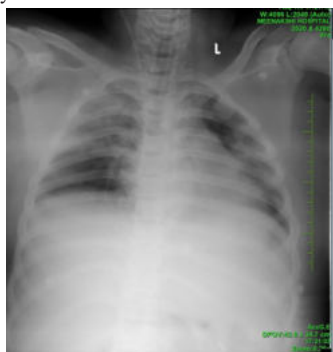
X-ray Of Case 3
